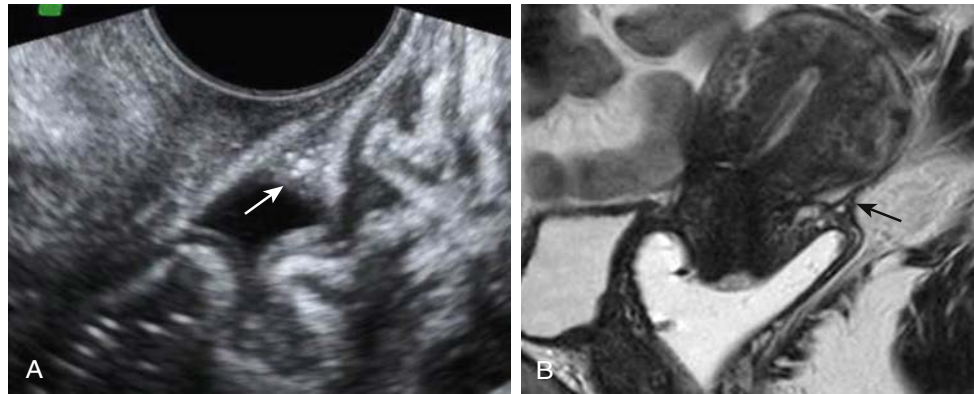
Retrocervical endometriosis attached to posterior vaginal fornix on vaginal ultrasound (A) and by MRI (B). Arrows show the lesions in different patients. (Courtesy of Manoel Goncalves, MD, Clinica Medicina da Mulher and RDO Medicina Diagnostica, and Mauricio Abrao, MD, University of Sao Paulo, Sao Paulo, Brazil.)
